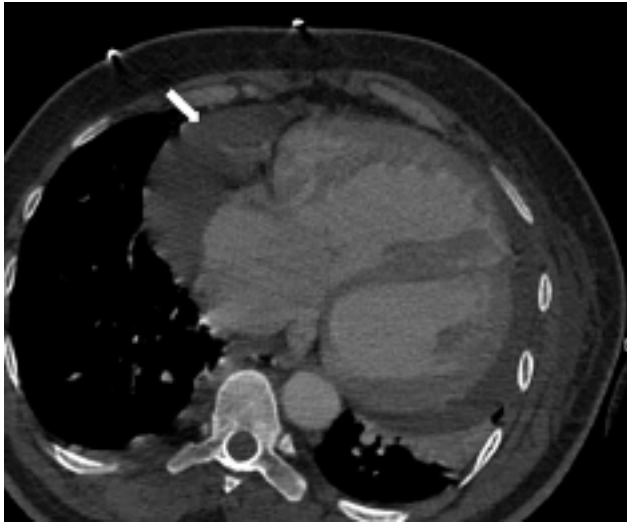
Axial CT image demonstrating an enlarged and hypertrophied right ventricle with flattening of the septum indicative of increased right sided heart pressures. Other findings include a moderate circumferential pericardial effusion (white arrow). CT, computed tomography.
